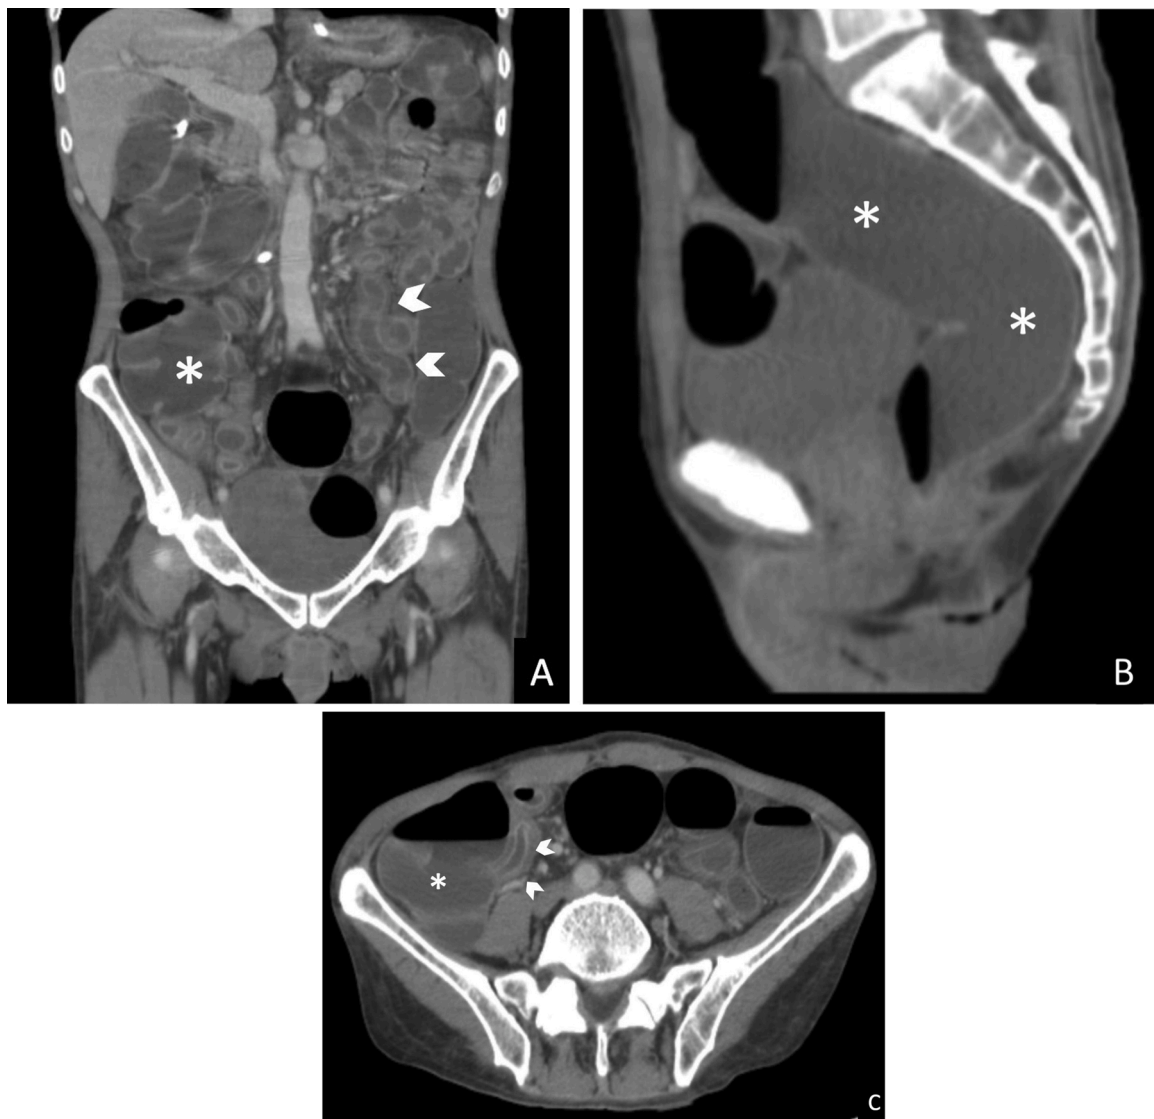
46-year old male with COVID-19. Portal phase contrast enhanced CT on coronal (A), sagittal (B) and axial (C) planes showing diffuse colonic and sigmoid distention (white asterisk) without mechanical or obstructive causes, associated with small bowel wall thickening and mucosal hyperenhancement (white arrow-heads), suggestive of adynamic ileus possibly due to direct viral inflammatory effect.
